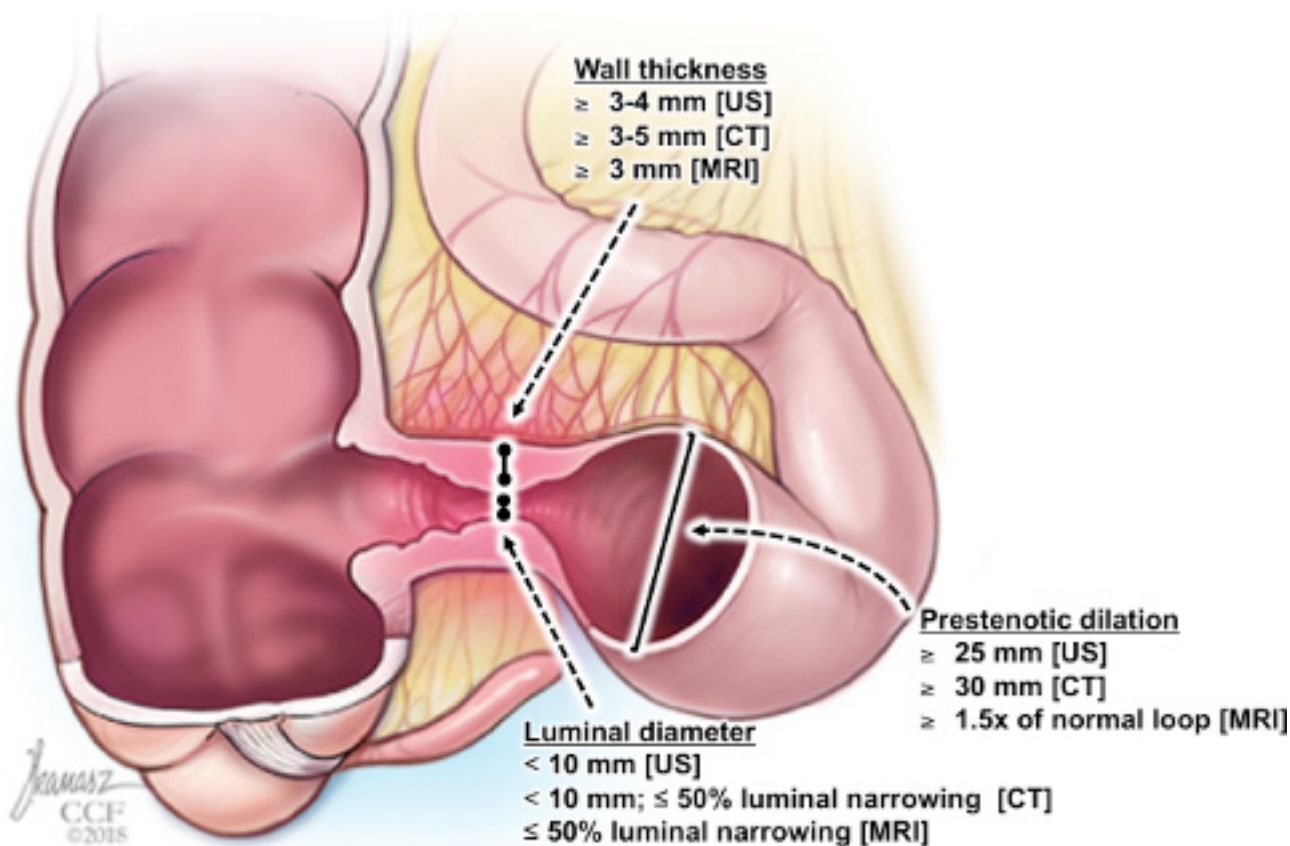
Proposed ranges for key items used for stricture detection in cross-sectional imaging modalities. US, ultrasound.
